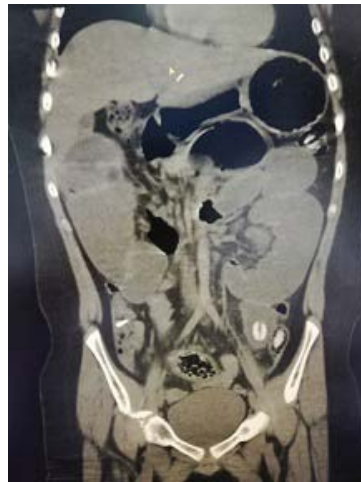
CT scan shows multiple radiolucent FB
